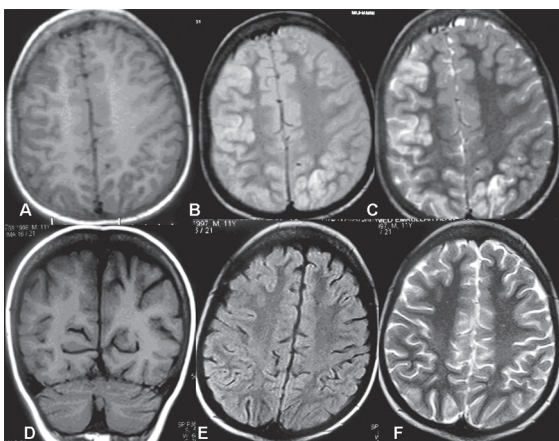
Axial T1-weighted (A), proton density (B), axial T2 (C), coronal T1 (D), axial FLAIR (E), and axial T2-weighted (F) MRI images revealed increased T2 signal at the cortical and subcortical region in the right frontoparietal and left occipital lobes (A-C). The lesions were completely resolved on follow-up MRI images obtained one month later on the initial exam (D-F).
